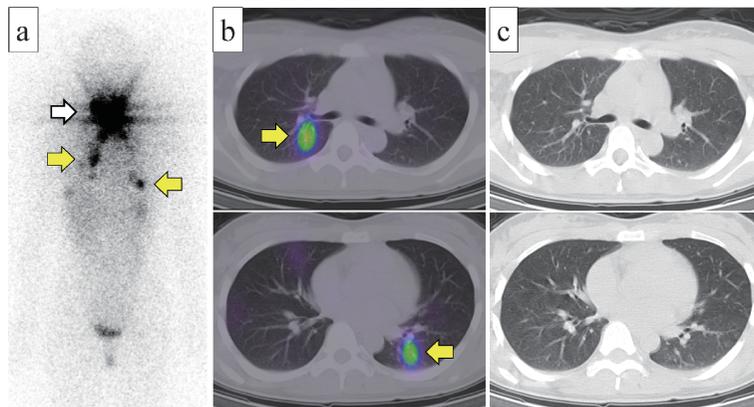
Whole body scan (WBS) and SPECT/CT after ablation therapy
